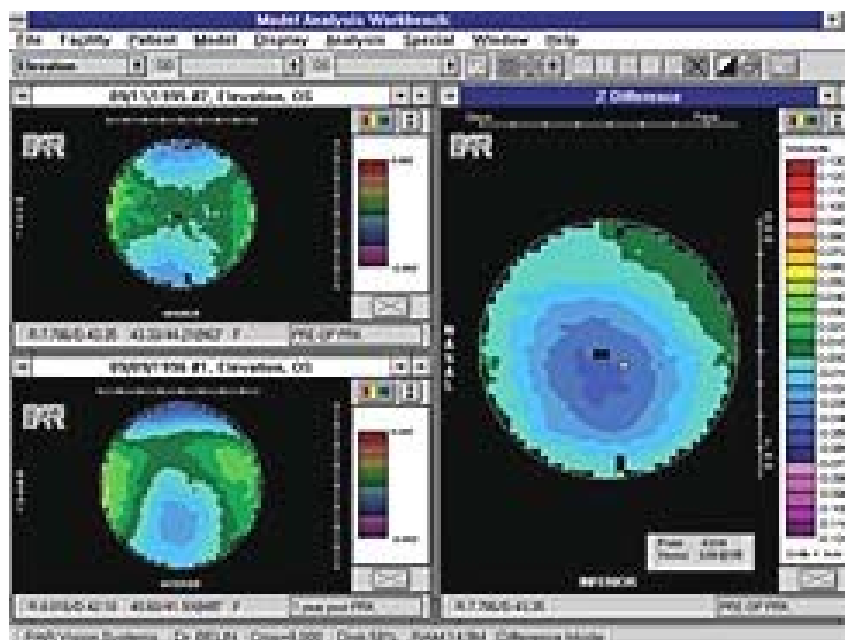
An elevation map from the now obsolete PAR CT system (Swartz et al., 2006)
